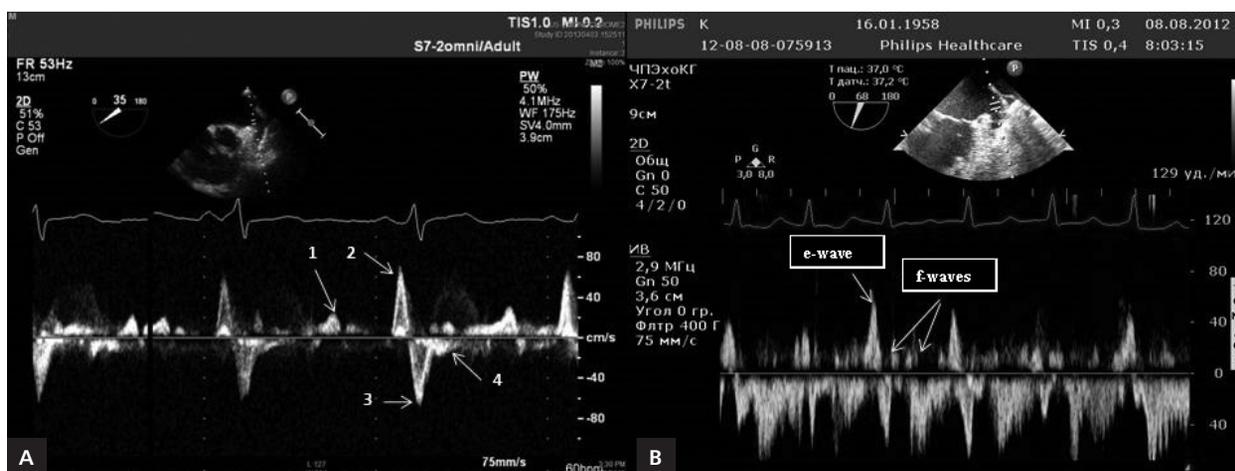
Left atrial appendage blood flow, detected by transoesophageal echocardiography: in the case of sinus rhythm (A: four-wave flow) and atrial fibrillation (B: two-wave flow)
